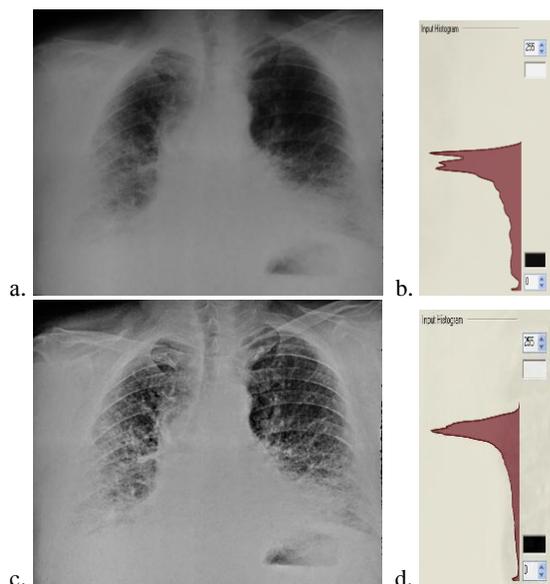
The underexposed X-ray image: a) a digitalized generic image and b) its histogram; c) the image after correction (without medical artifacts) and d) its histogram.
